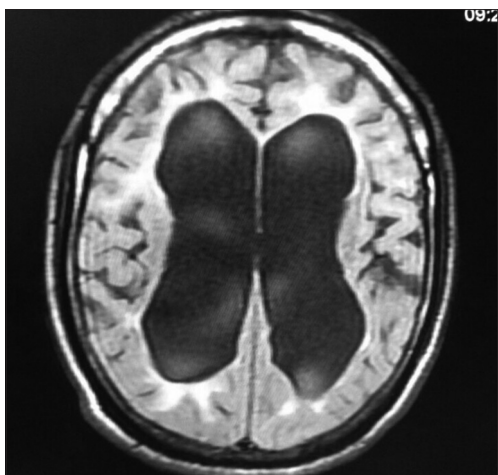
MRI T2 FLAIR axial image showing diffuse cerebral atrophy and white matter hyperintensity representing demyelination/hypomyelination of white matter
